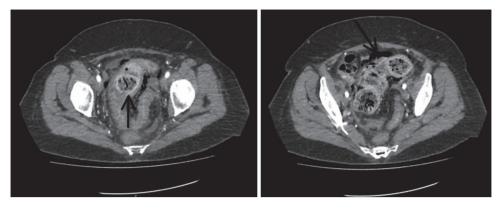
Abdominal computed tomography scan shows pneumoperitoneum with enhancement of the distal sigmoid and rectum with faecal impaction.
